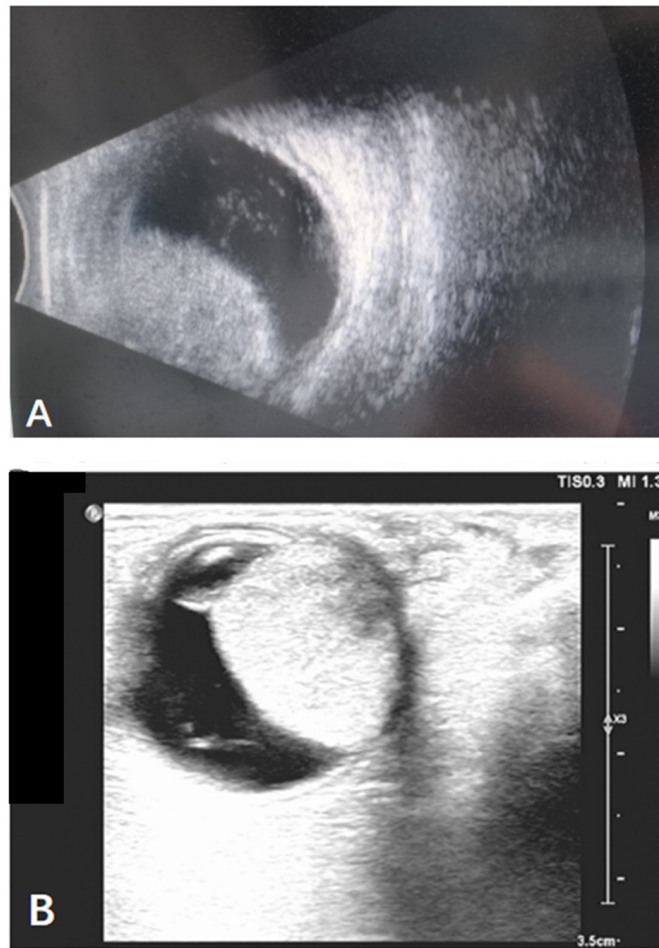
Ophthalmic B-scan and color Doppler ultrasound examination images. (A) B-scan ultrasound image of the right eye, showing a hemispherical mass in the vitreous cavity. (B) Ultrasound image of the right eye, depicting a solid intraocular mass compressing the lens, with clear boundaries.
